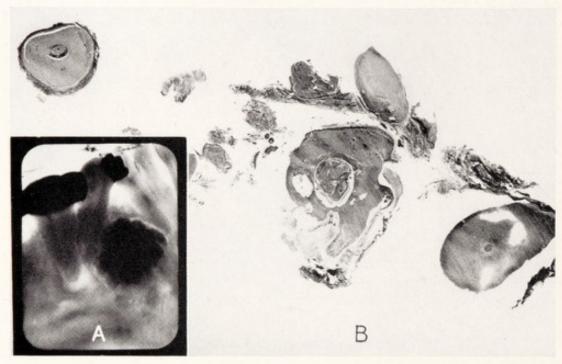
Odontoma: A, x-ray findings showing a conglomeration replacing a tooth; B, cross-section of some of the small elements making up the mass.
